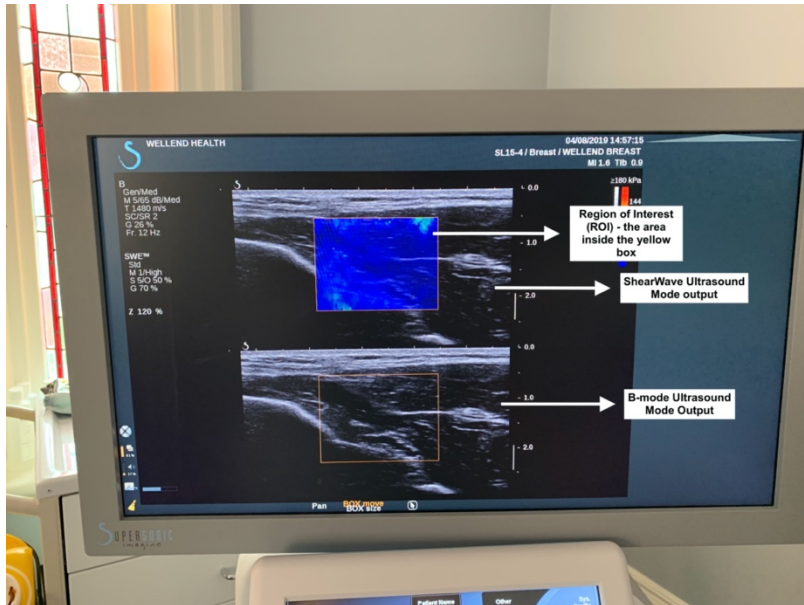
SuperSonic™ Imagine Aixplorer® SWE machine output with the ShearWave Elastography mode and B-mode ultrasound simultaneously visible on the machines output screen. The Region of Interest is the focal point of the ShearWave Ultrasound
